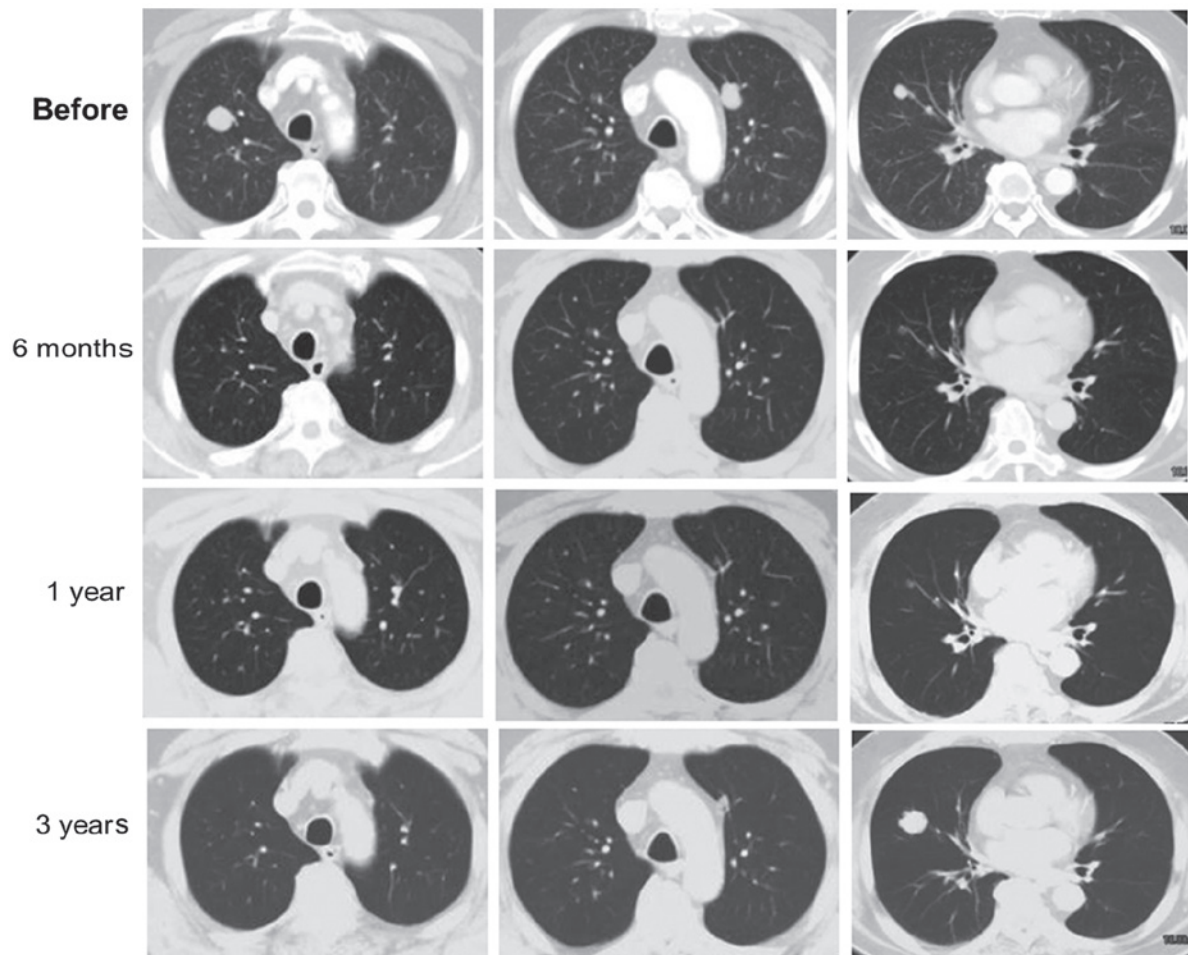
Time-course computed tomography of a patient who received S-1 treatment and exhibited a good response to S-1 combination therapy. The multiple lung metastases almost disappeared, although some relapse has appeared.
